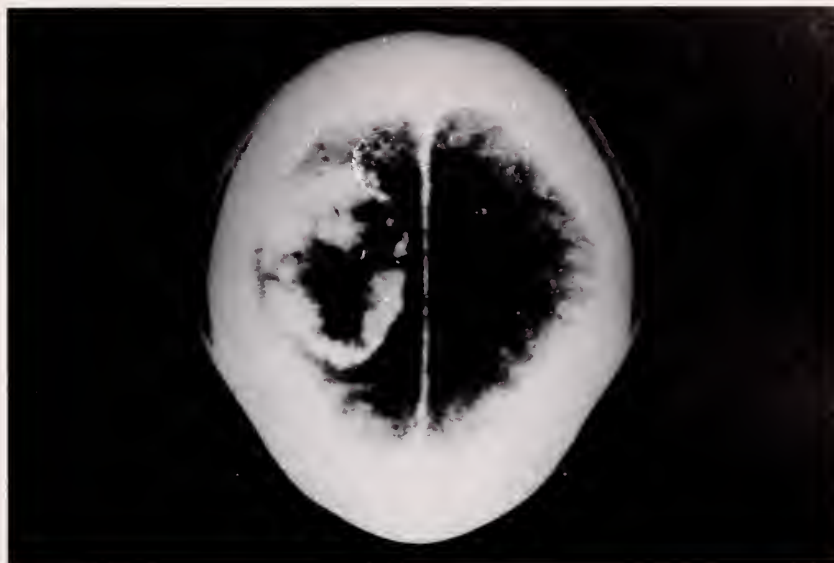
CT scan of the brain showing metastatic adult Wilms' tumor to the left temporo-parietal region.
